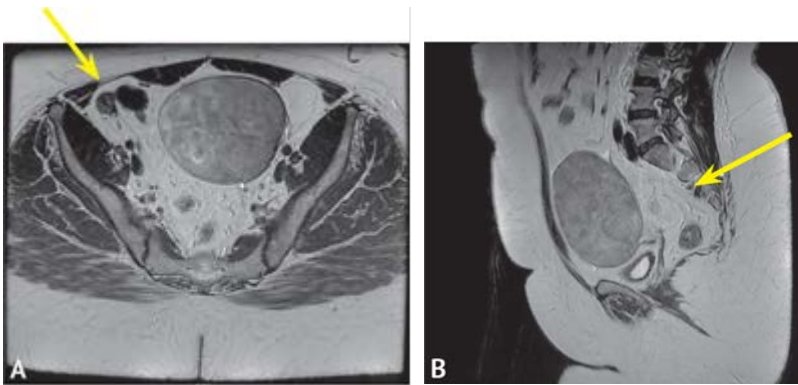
Magnetic resonance imaging of the pelvic organs; A — right gonad (arrow), oval, 7×3×3 cm in size, heterogeneous structure, with clear contours; B — left gonad (arrow), 17×18×19 cm in size, with clear, uneven contours, heterogeneous structure, with calcified inclusions
